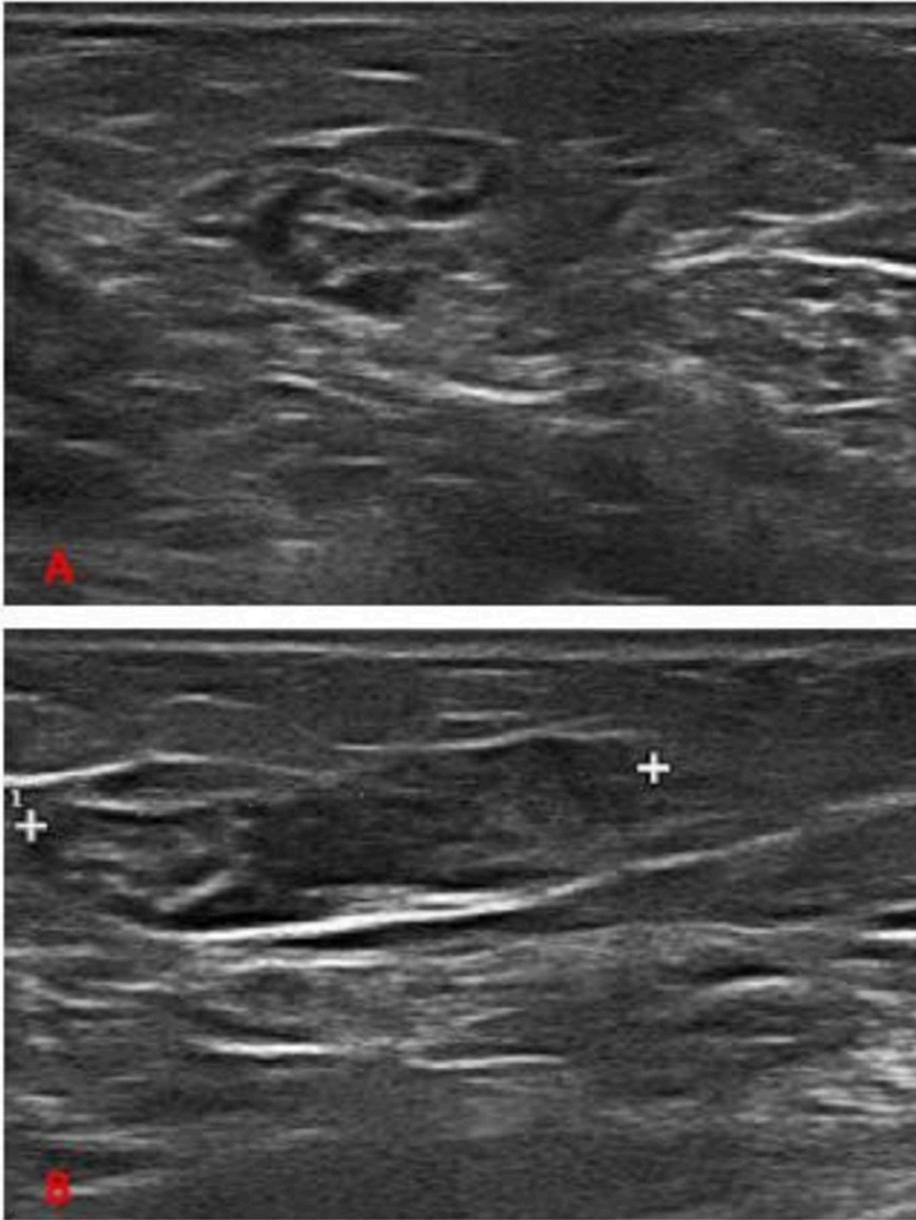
US (ultrasound) in the same woman shows suspicious right axillary node with cortical thickening. Non-Hodgkin lymphoma was proven on US-guided core biopsy.
